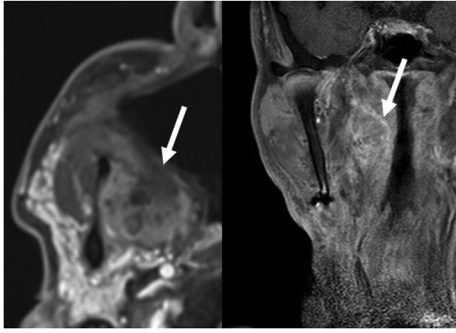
Type of recurrence (shown in enhanced magnetic resonance images). Buccinatopharyngeus muscle recurrence: 69-year-old male; mandibular gingival cancer (T4aNOM0) (right). Internal or external pterygoid muscle recurrence: 48-year old, male; maxillary gingival cancer (T4aNOM0) (left). White arrow: Tumor.
